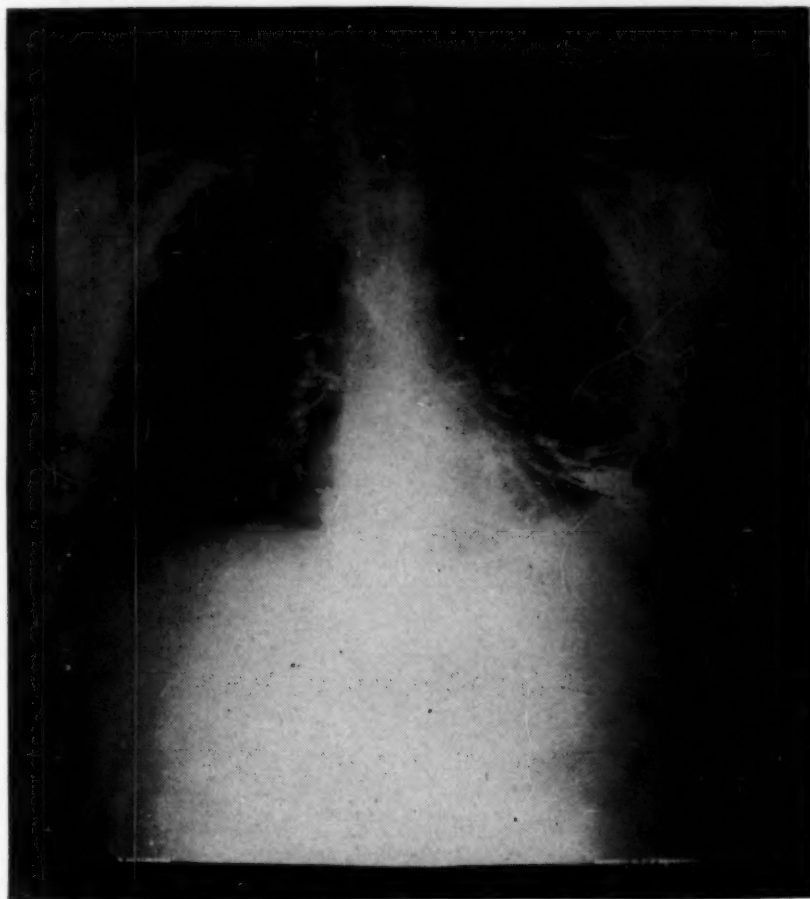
Figure I (A): Roentgenogram showing cyst of lung in the dorsal division of the left lower lobe.
